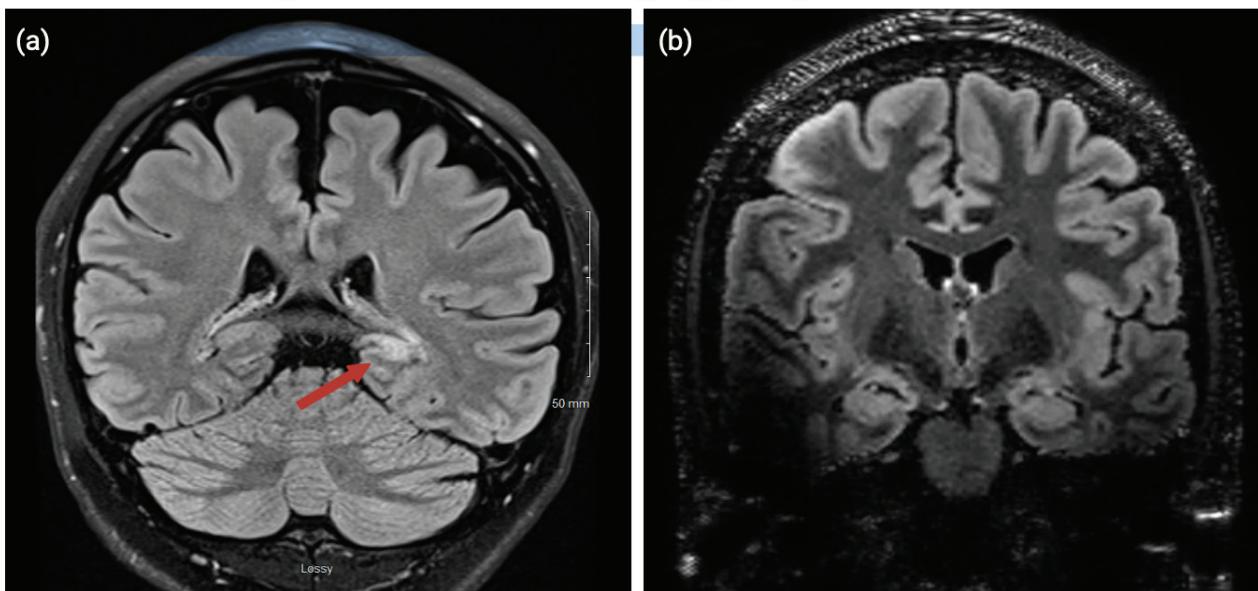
The above images show coronal sections of MRI brain in (a) our patient and allows for comparison to (b) a healthy, age-matched control. The red arrow point to an area of subtle T2-Fluid Attenuation Inversion Recovery (FLAIR) hyperintensity within the left mesial temporal lobe of (a) our patient. These findings are consistent with left mesial temporal lobe sclerosis, a common finding seen in patients with focal epilepsy.
